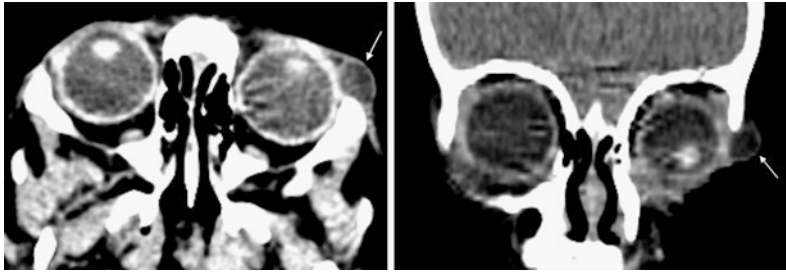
Paraorbital preseptal dermoid cyst in an infant girl. a–b Axial and coronal CT images show a small well-defined subcutaneous hypodense fat density lesion seen at the supero-lateral aspect of the orbit along the fronto-zygomatic suture (arrow)
